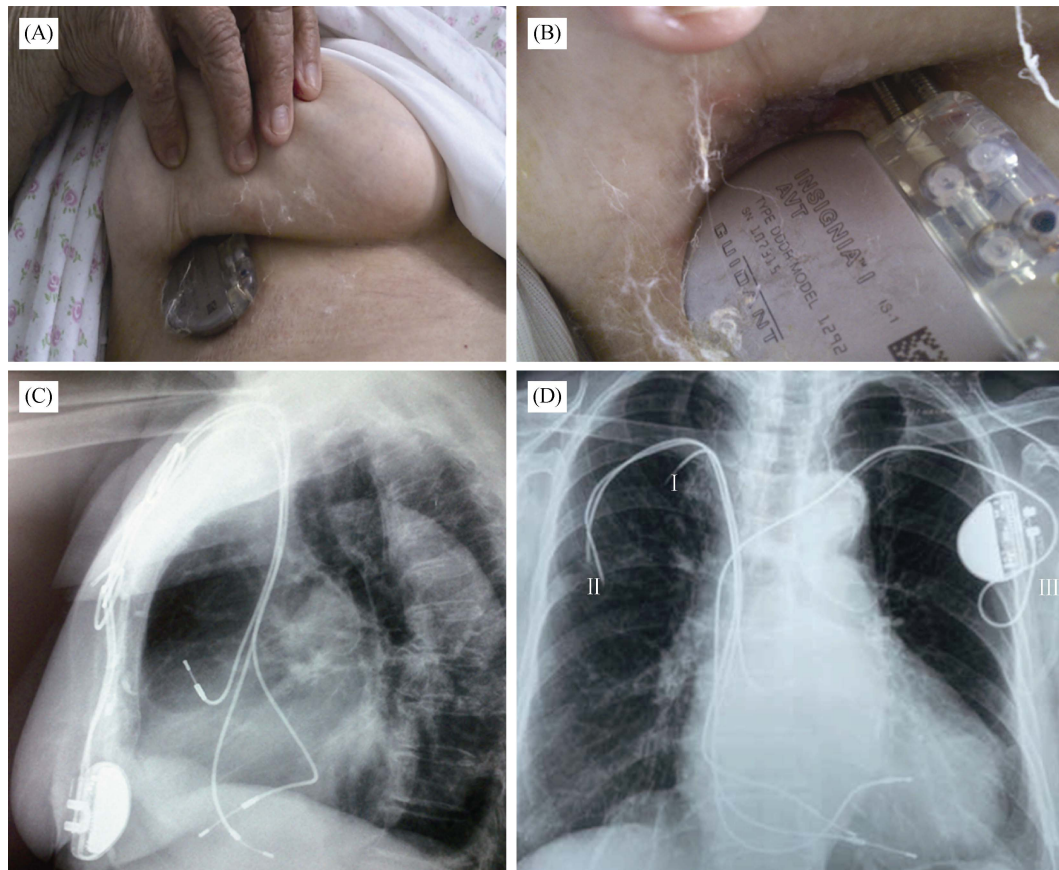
Clinical images and X-rays. (A): Display of pacemaker’s generator upon the elevation of the right breast; (B): detailed view of the skin tunnel’s entrance. Note the cotton flakes that the patient used to cover the opening; (C): X-ray chest film, lateral view showing the external position of the device; and (D): X-ray chest film poster anterior view, ten days after the re-installment of the pacemaker. I presented as initial pocket of the VVIR pacemaker. II presented as re-implantation pocket of the DDDR device leading to tunnel formation and complete generator extrusion. III presented as final re-implantation on the left side.
